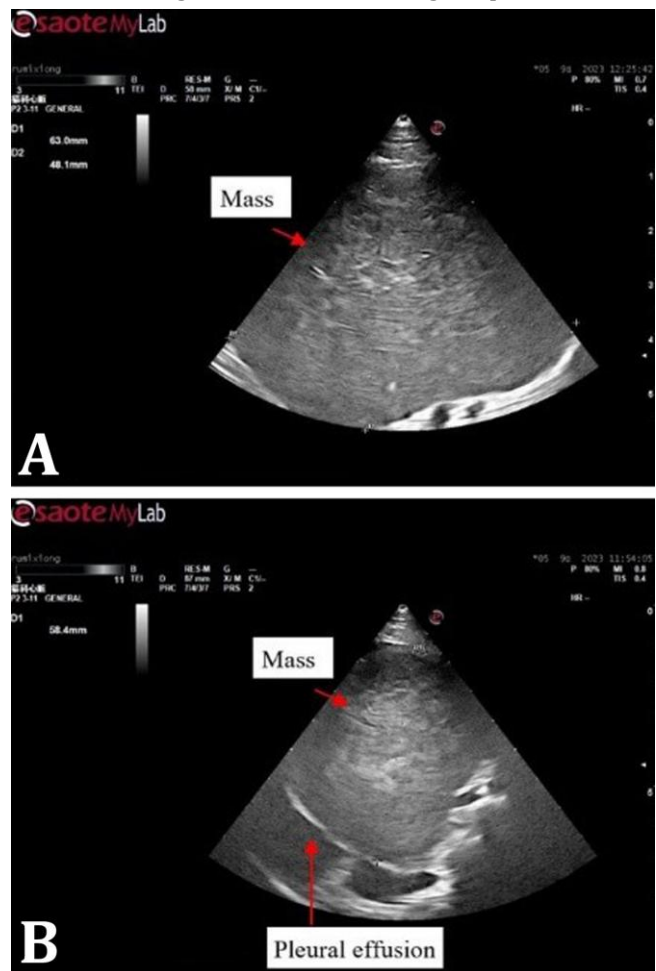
Thoracic ultrasound revealed, A) a mild hypo-echoic mass at the right para-sternal apex with the size of 63.00 × 48.10 mm, and B) a large amount of pleural effusion in the thoracic cavity.
